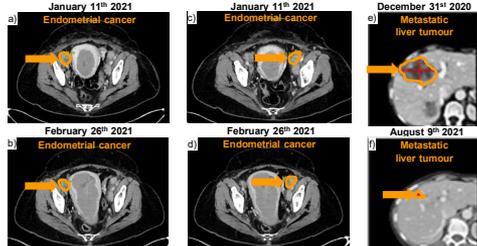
CT scans of a V1/V2 heterozygous 72-year-old female patient with endometrial cancer; right iliac before (a) and after (b) and left iliac before (c) and after (d) treatment with BI 765063 and ezabenzimab; a V1/V1 homozygous 44-year-old female patient with MSS CRC; liver segment before (e) and after (f) treatment with BI 765063 and ezabenzimab
